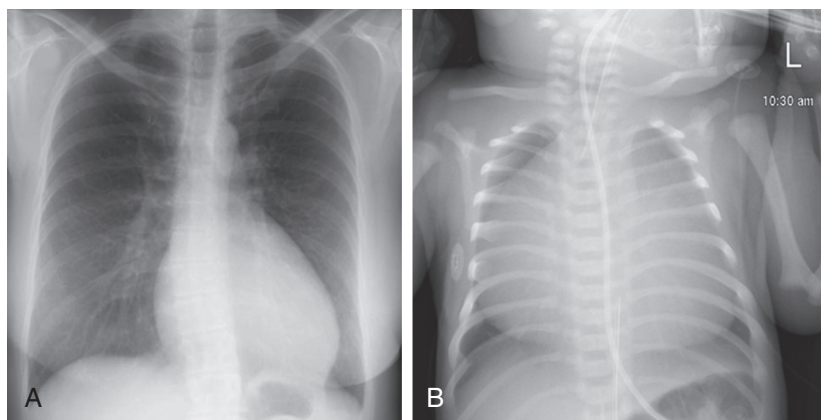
■ A, Chest radiograph of a patient with Ebstein malformation with severe tricuspid regurgitation and a small atrial septal defect before tricuspid valve surgery. B, Cardiomegaly, a narrow waist, and a cardiothoracic ratio of 0.56 in a neonate with Ebstein malformation showing massive cardiomegaly (“wall-to-wall” heart). (From Said SM, Dearani JA: Ebstein anomaly, congenital tricuspid valve regurgitation and dysplasia. In Allen HD, Driscolle DJ, Shaddy RE, Feltes TF, editors: *Moss and Adams’ heart disease in infants, children, and adolescents*, ed 8, Philadelphia, 2013, Lippincott Williams & Wilkins, Figures 39-11 and 39-12.)
